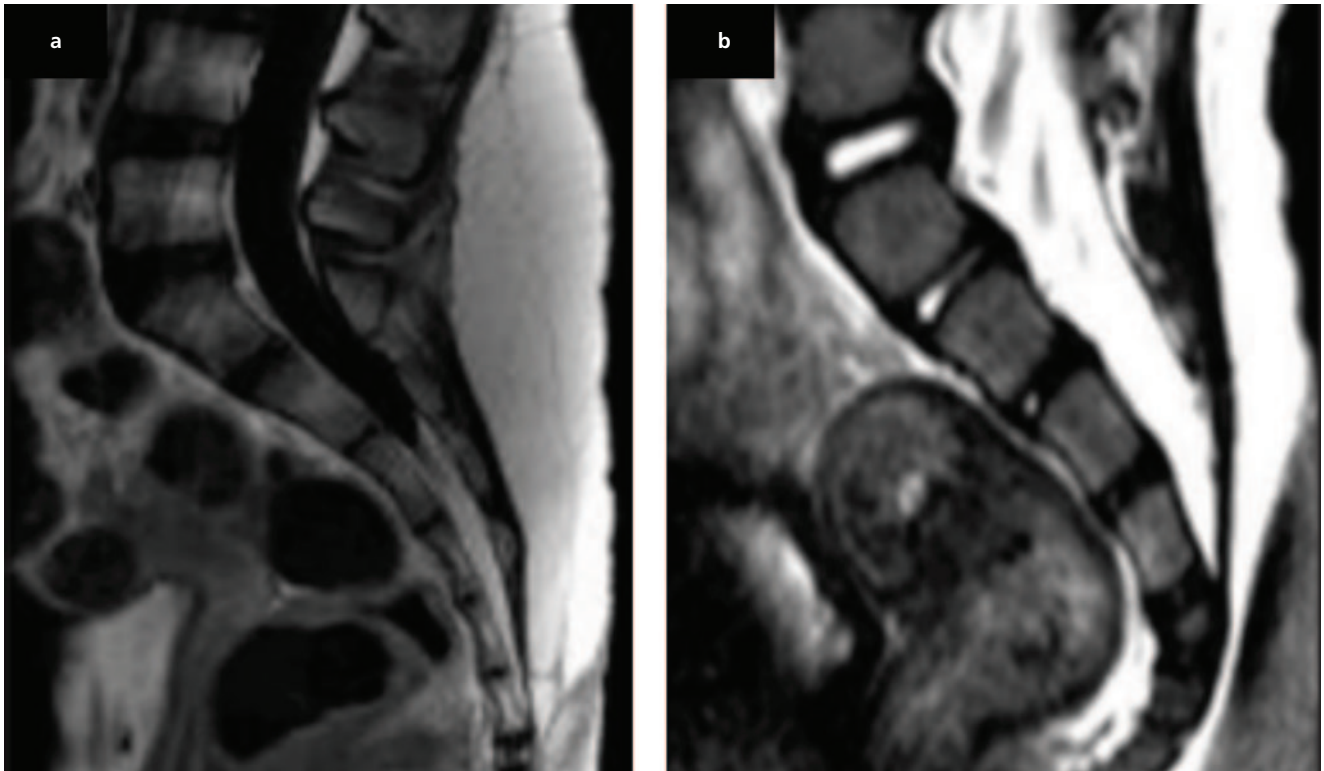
Type 1 coccyx (a) and Type 2 (b) coccyx are shown on sagittal MRI section.
